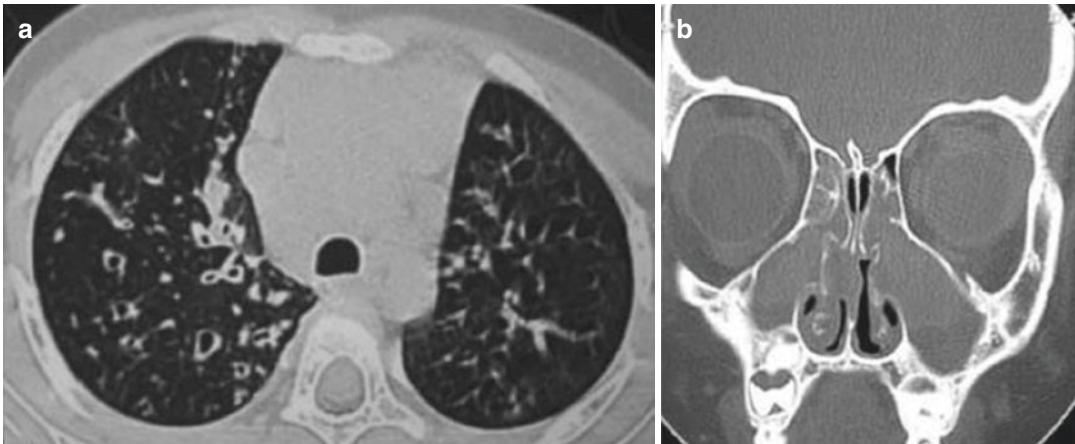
Cystic fibrosis a 5-year-old child. A chest CT scan (a) shows multiple cylindrical bronchiectases in the right lung. A coronal CT scan (b) shows maxillary sinuses and ethmoidal sinuses filled with fluid and mucosal edema
